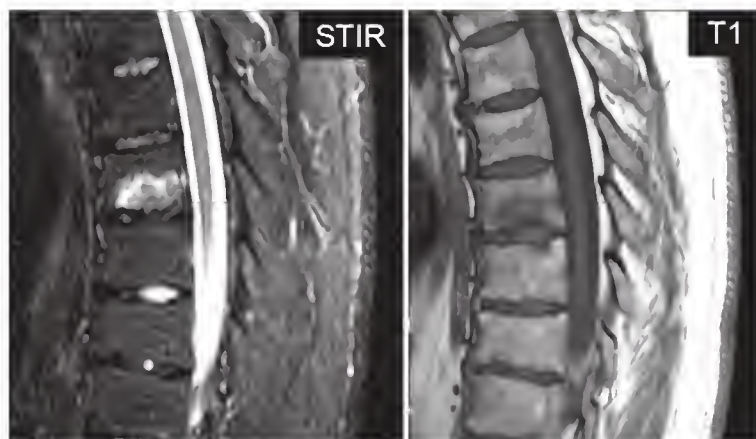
(Abacterial) spondylodiskitis (formerly known as Andersson lesion) in established AS, typically recognized by a circumscribed hemispherical erosive lesion surrounded by bone marrow edema in STIR and the corresponding hypointense signal in T1-weighted MRI.
